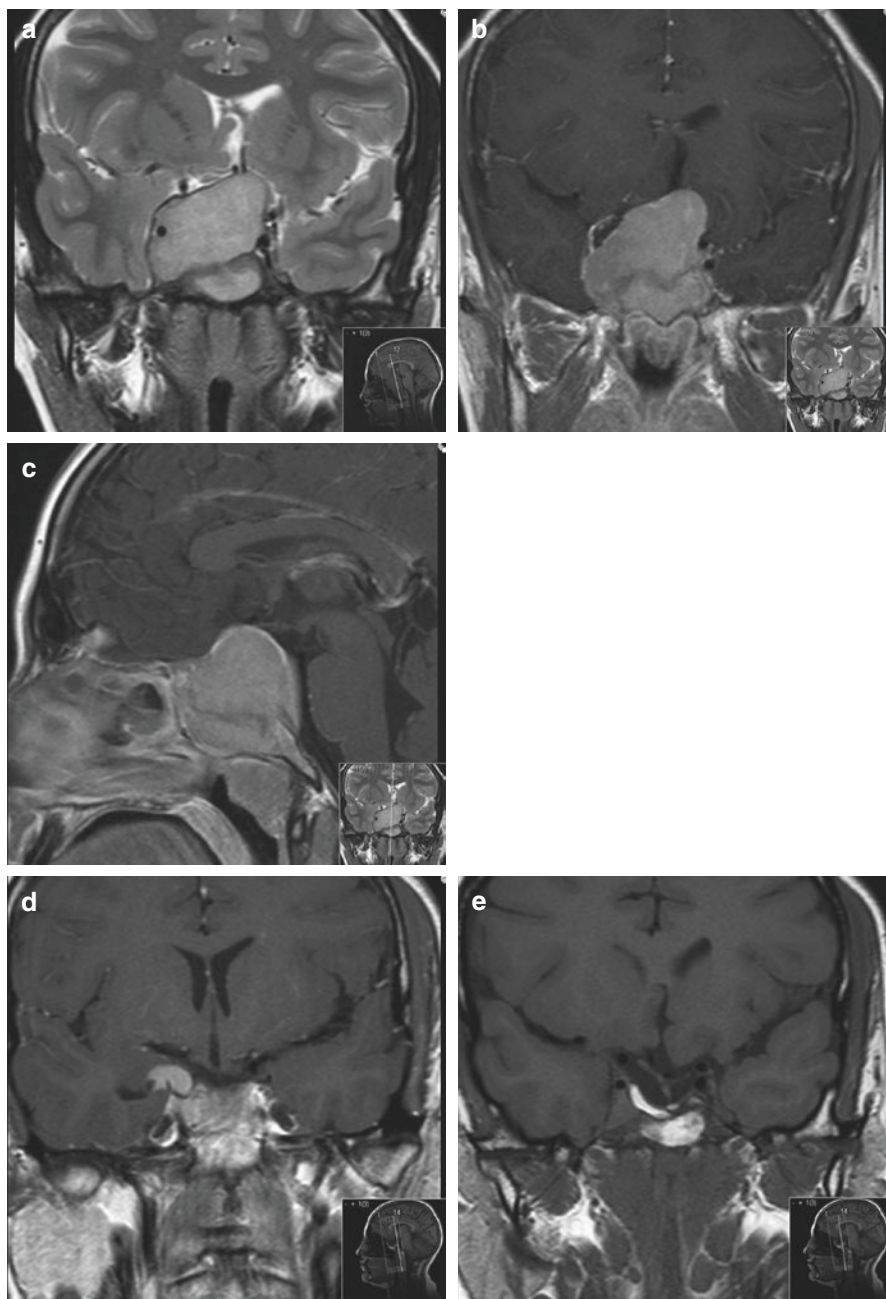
(a) Coronal T2 weighted MRI at diagnosis, showing an enormous lesion arising from the pituitary fossa and extending up to cause the chiasm to splay and to compress the third ventricle. The lesion shows uniform enhancement (b, c) with gadolinium. MRI more recently, showing (d) invasion of the right mesial temporal lobe, and (e) “tenting” of the chiasm
